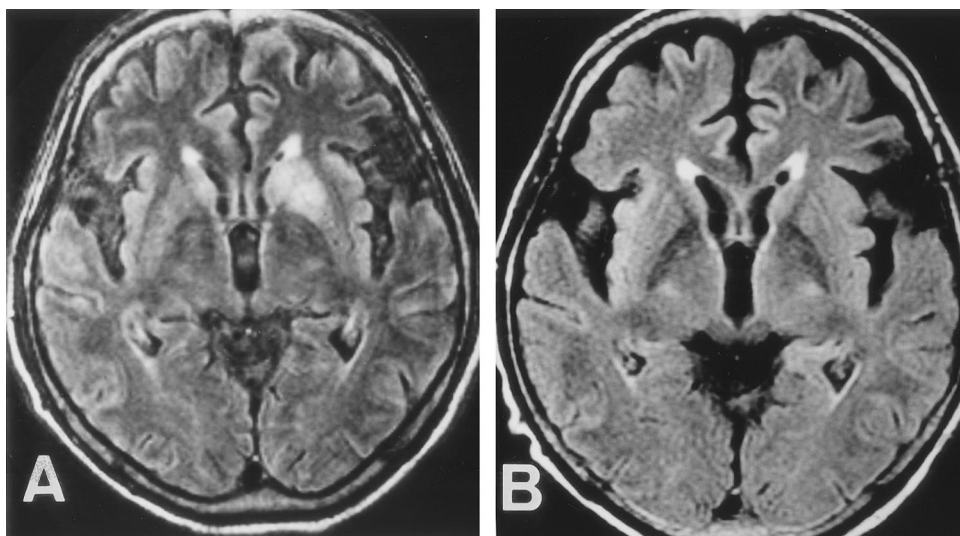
Axial fluid-attenuated inversion recovery (FLAIR) brain MRI showed hyperintense signals in bilateral caudate and the left putamen nuclei (A), but no medial temporal lobe abnormalities. No abnormal contrast enhancement was observed (not shown). After six cycles of chemotherapy (carboplatin and etoposide), MRI revealed complete disappearance of the brain lesions (B).
